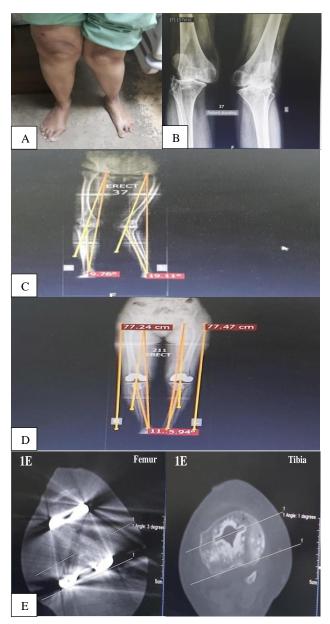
(A-E): Patient with rheumatoid arthritis and morbid obesity with windswept knees, varus [R] and valgus [L], requiring primary TKA. X-rays knee, AP view with patient standing, showing grade 4 osteoarthritic changes bilaterally. Standing long leg films/ orthoscanograms showing measurement of HKA angle, both preoperatively and post-op. HKA angle has been bilaterally corrected to varus after primary TKA [R>L]. Axial CT scans after primary TKA showed normal rotational alignment of components [femur and tibia]; CER<10 degrees. Post-op recovery was uneventful with physiotherapy and rehabilitation; but at 3 months the patient experienced a minor trauma while lifting an object from the ground, which led to a feeling of clicking sensation inside the right prosthetic knee, with progressive swelling and persistent pain around the joint. X rays AP view of knees showed supracondylar fracture of the medial condyle of the femur of the right side, with anterior femoral notching and fracture line extending to the femoral component (Figure 2); and partially extending proximally (Figure 4). Axial CT scans showed a complete comminuted fracture of the right medial condyle of the femoral component of the implant (Figure 3). 3D reconstruction image of this type of fracture showed a complete comminuted fracture of the right medial condyle of the femoral component, with the supracondylar fracture (Figure 4).
